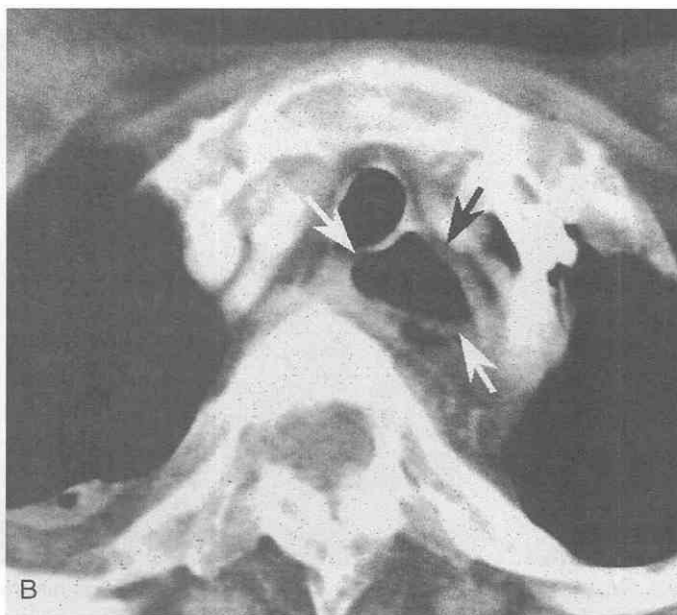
Zenker's diverticulum. A, Esophagography demonstrates a barium-filled outpouching lesion from the esophagus. B, CT scan shows air-filled structures (arrows) anterior to the esophagus.
